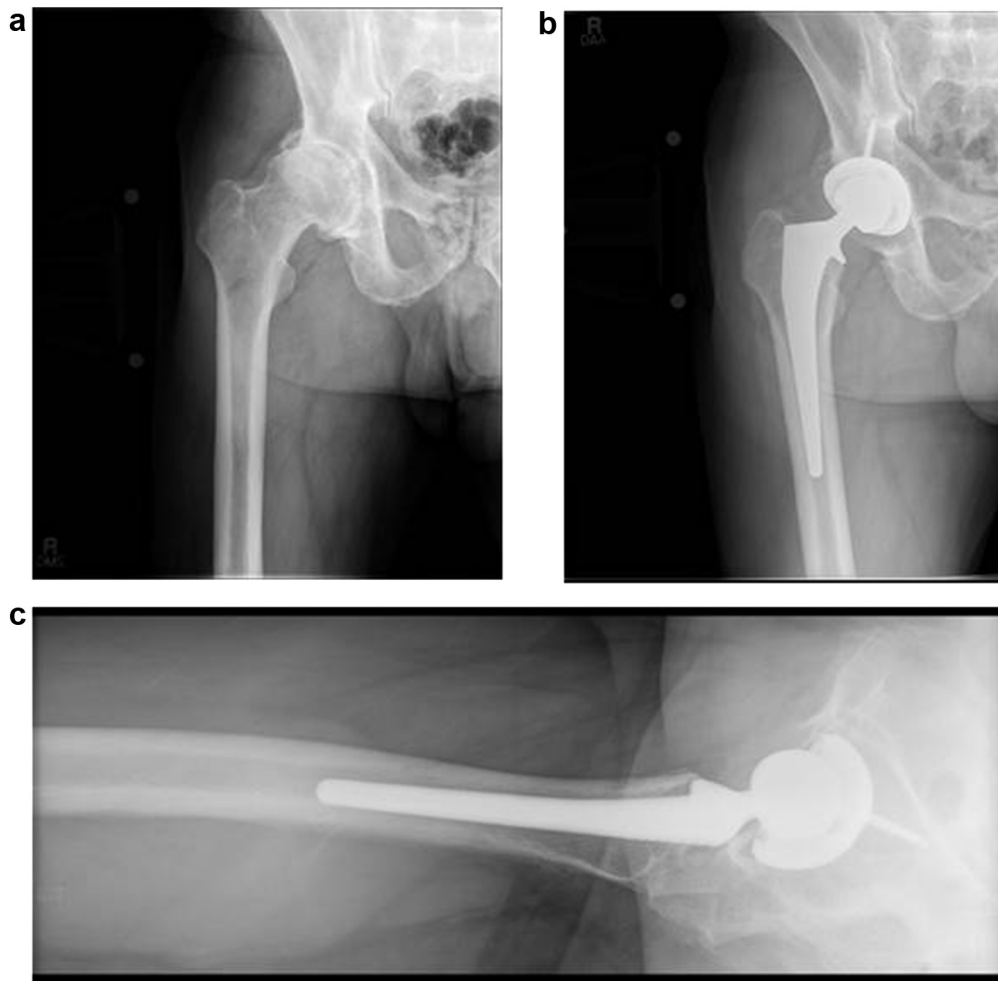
Preoperative anteroposterior (AP) (a), postoperative AP (b), and cross-table lateral (c) radiographic imaging of the right hip. Implant positioning postoperatively is found to be optimal.
